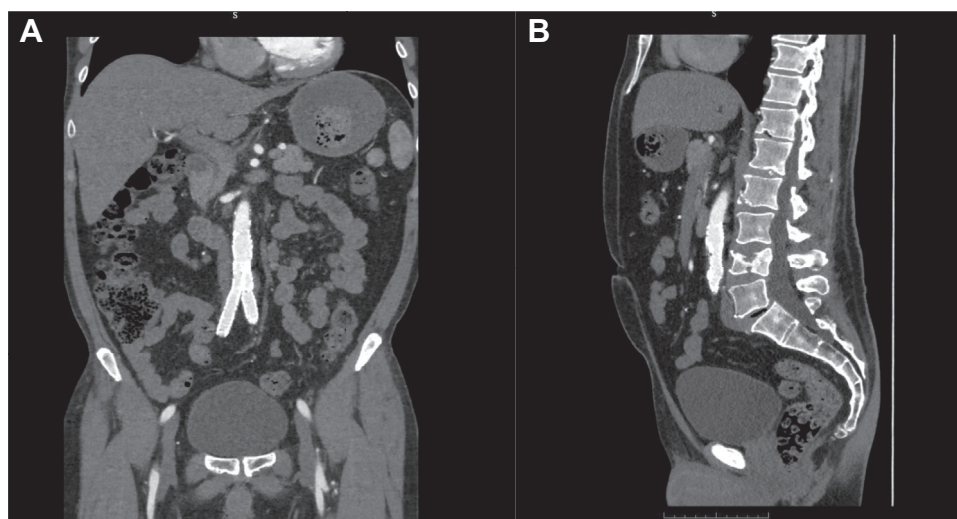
Surveillance computed tomography angiogram 4 months after the procedure demonstrating the iliac branch endoprosthesis without evidence of endoleak or migration in the coronal (A) and sagittal (B) projections.
